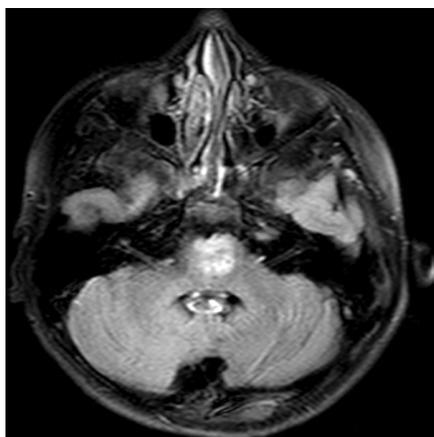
Axial and sagittal MR images of a patient with DIPG (Part 1).
